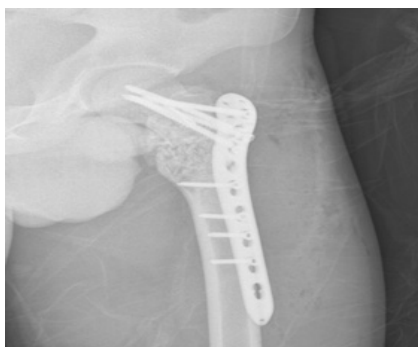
Postoperative radiograph following the first curettage-grafting and fixation
